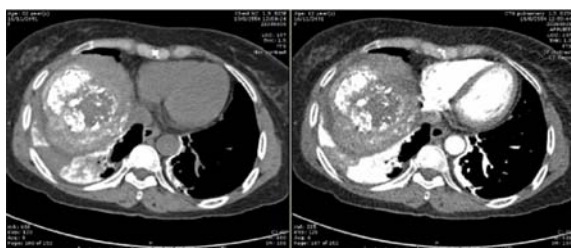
CT with (right) and without (left) contrast showed lipiodol deposition at bilateral lower lung fields
